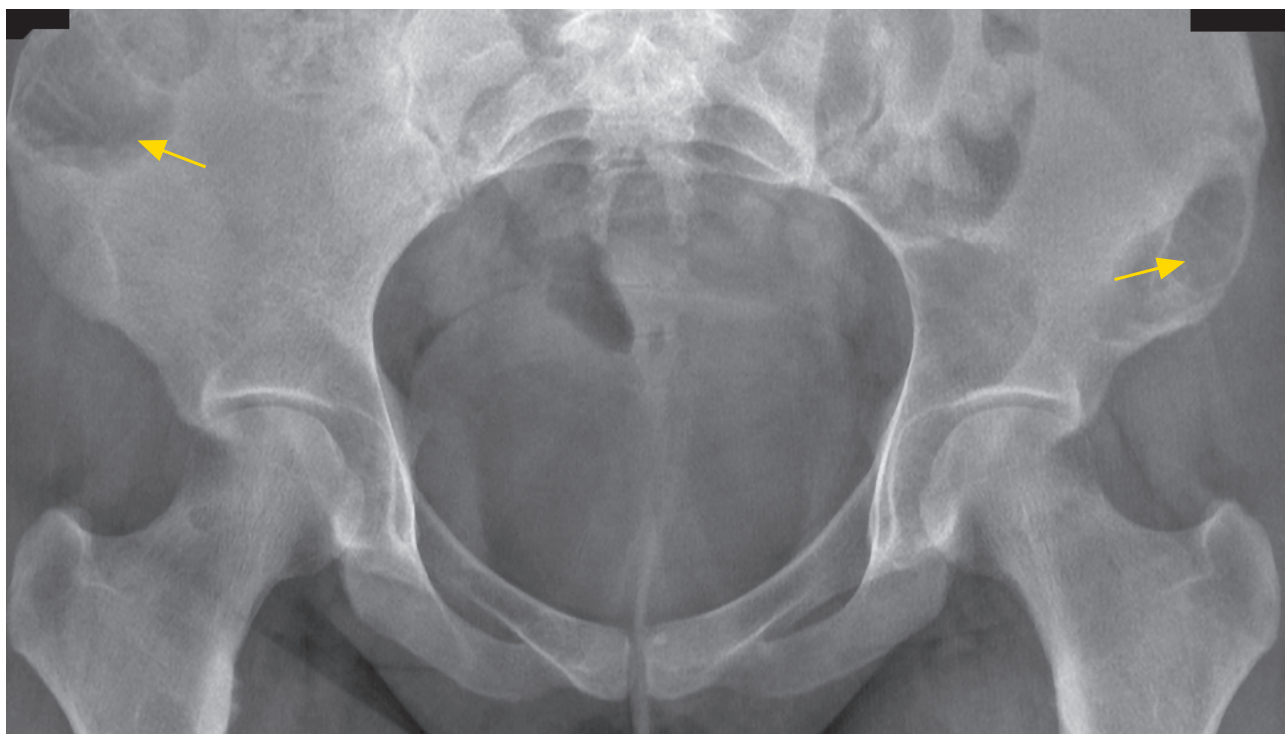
Hip x-ray (yellow arrows – lytic bone lesions on iliac bone)
